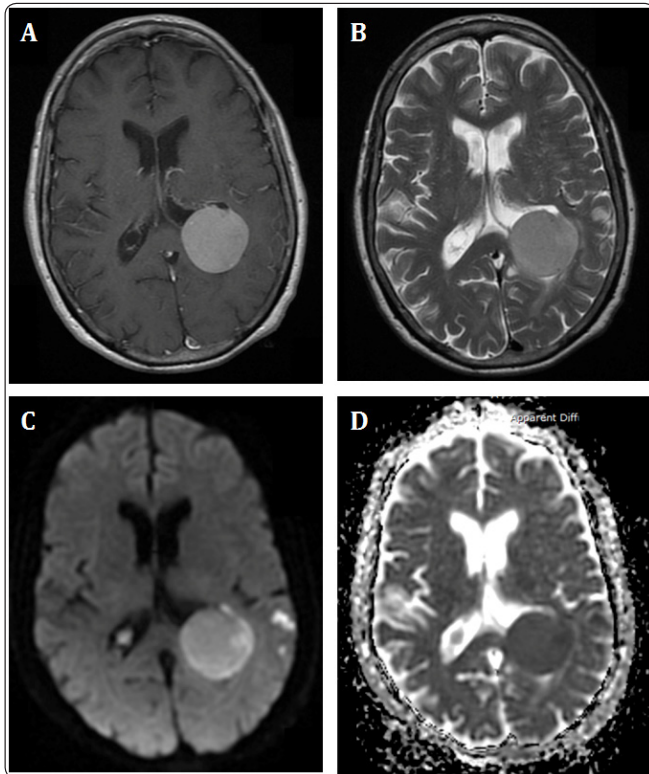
Axial sections of a gadolinium contrast-enhanced MRI brain scan. A and B) T1-weighted and T2-weighted sequences, respectively, showing a well-demarcated uniformly enhancing meningioma distending the posterior horn of the left lateral ventricle. C and D) DWI and ADC sequences, respectively, showing restricted diffusion within the left inferior parietal cortex, consistent with an infarct. MRI - Magnetic Resonance Imaging. DWI – Diffusion-weighted imaging. ADC – Apparent Diffusion Co-efficient.
